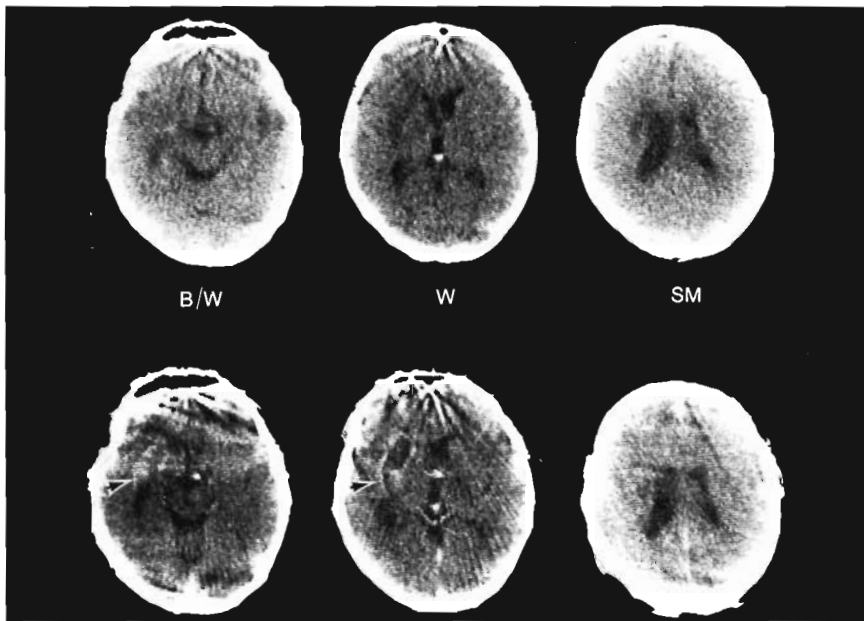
Computed tomographic scans (case 4) done four months after stroke without contrast enhancement (top) and with contrast enhancement (bottom). Subcortical lesion site with hemorrhagic etiology is capsular/putaminal with posterior extension. Arrows indicate posterior lesion extension across auditory radiations in temporal isthmus. Note that although scan was done at near-horizontal angle, location of temporal isthmus is still anterior to temporal horn on slice B/W and anterior to atrium on slice W.
